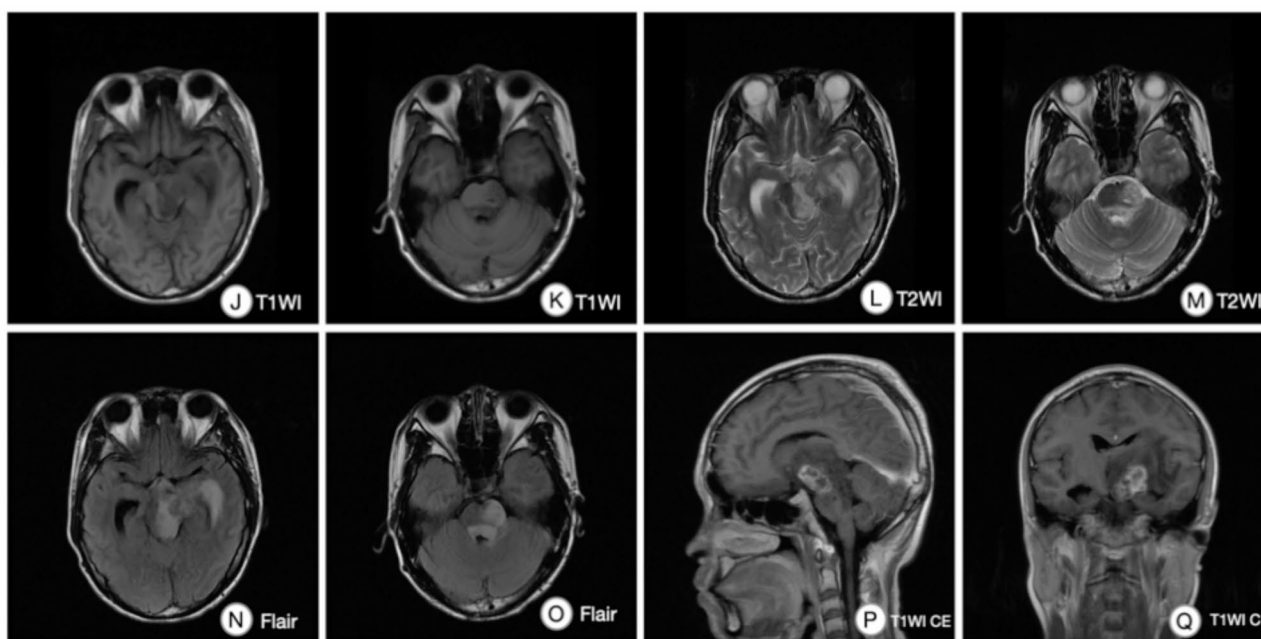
Non-contrast MRI shows patchy prolonged T1/T2 signals in the left diencephalon, pons, and fourth ventricle periphery (J-M), with FLAIR hyperintensity (N, O) and heterogeneous ring-like enhancement post-contrast. Coronal imaging reveals the “cascade sign” (P, Q)
